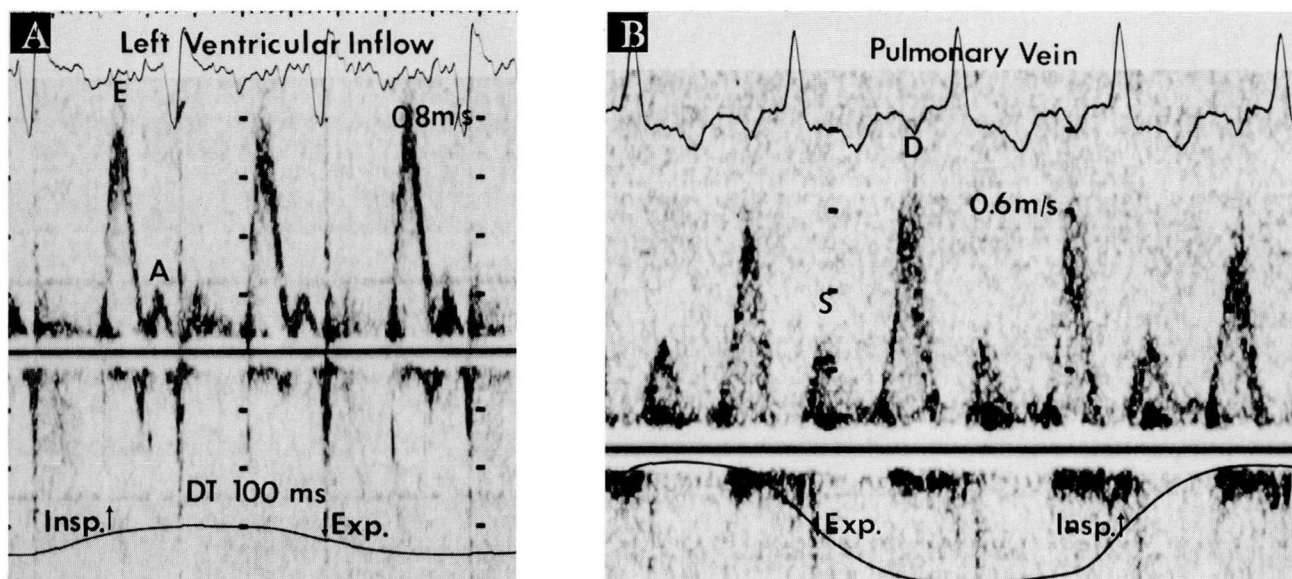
Restrictive flow patterns of left ventricular inflow in advanced cardiac amyloidosis. A. Pulsed-wave Doppler recording of a left ventricular inflow profile with an increased E/A ratio (4.5) and short deceleration time (100 milliseconds). B. Pulsed-wave Doppler recording of a right upper pulmonary vein flow profile with decreased peak forward systolic (S) and increased peak diastolic (D) velocities. The left-sided flow velocities are influenced minimally by respiration.
